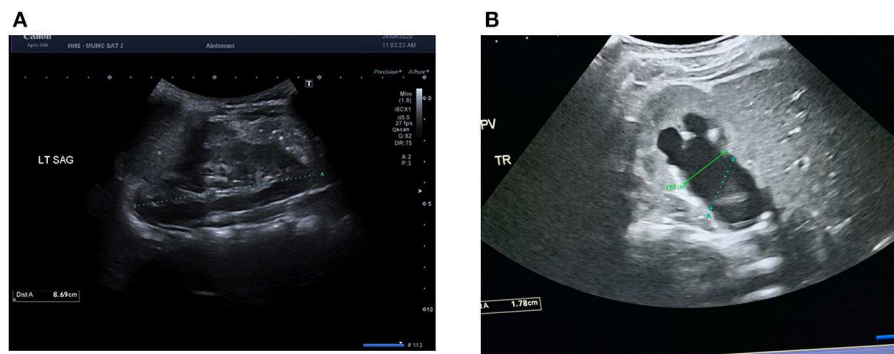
Example measurements of ultrasound renal parameters for the Pyeloplasty Prediction Score in (A) longitudinal view of the left kidney with electronic calipers measuring renal length as the maximal distance between the upper and lower poles and (B) transverse view of the right kidney with green electronic calipers measuring true anteroposterior diameter (APD) as the distance between the parenchymal lips at the renal hilum in the mid-section. Blue electronic calipers represent the incorrect method of measuring APD as the calipers are not aligned to the parenchymal lips.
